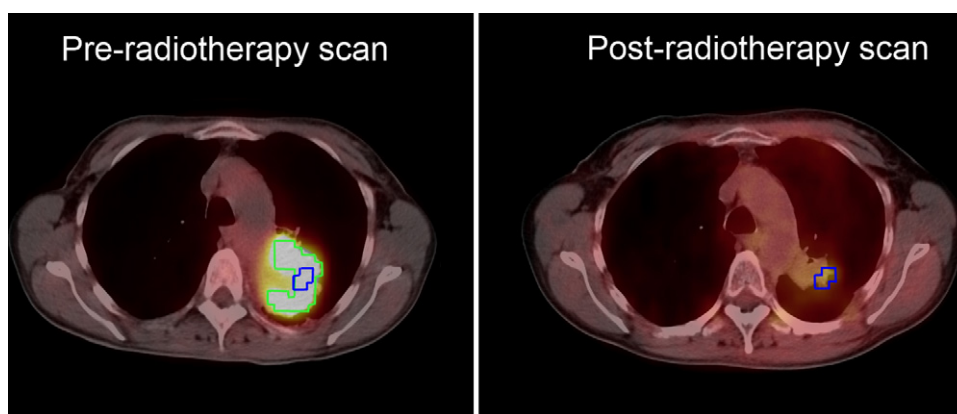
Representative FDG-PET-CT images of a patient pre- and post-radiotherapy. The green lines indicate the 50% SUV_{max} FDG high uptake area pre-radiotherapy. The blue lines indicate the residual metabolic active areas post-radiotherapy, also transposed on the pre-radiotherapy scan. Visual evaluation shows a large correspondence between the residual areas post-radiotherapy with the high FDG uptake areas pre-radiotherapy.
